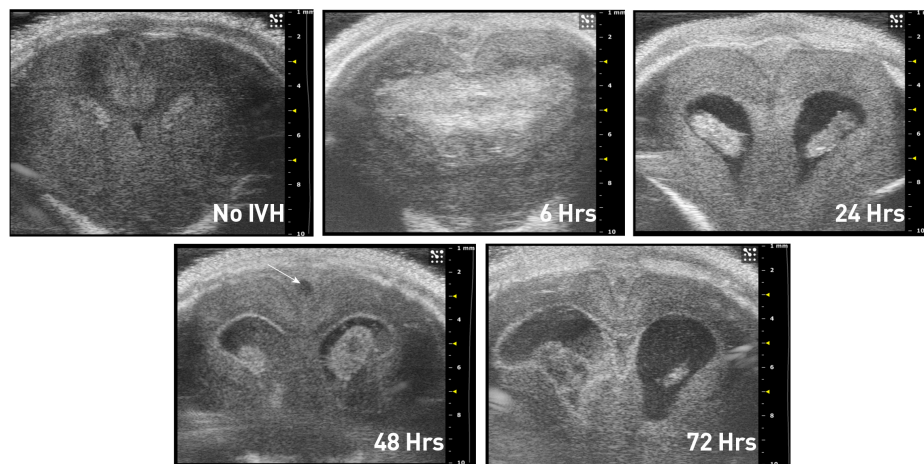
Development of PHVD in rabbit pups as seen on cranial ultrasound
